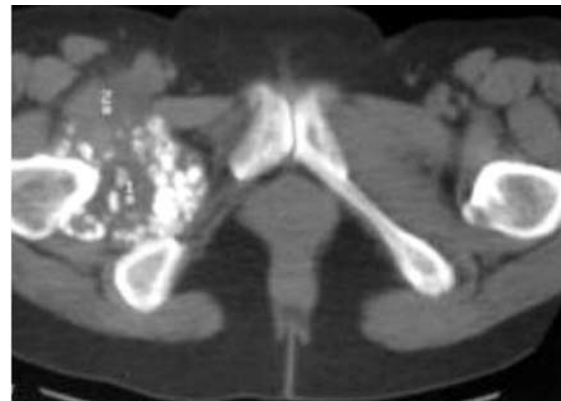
Axial CT image of the hips in a 54-year-old man with synovial osteochondromatosis shows multiple ossified loose bodies confined within the capsular margins of the effusion-distended right hip joint.
